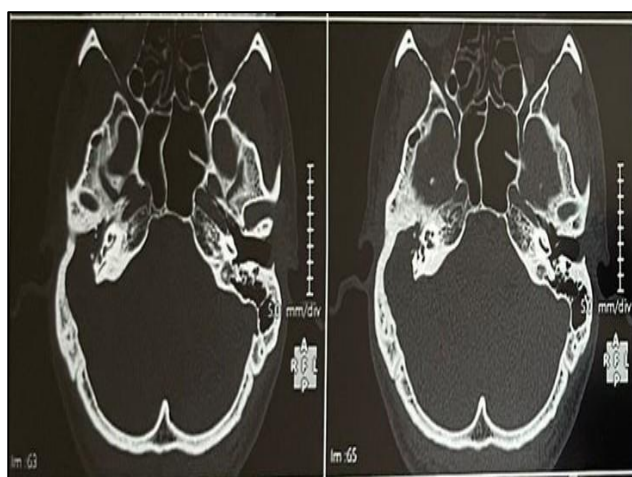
Axial section of HRCT temporal bone showing extensive abnormal soft tissue in right middle ear and mastoid cavity with erosion of sigmoid sinus plate.
